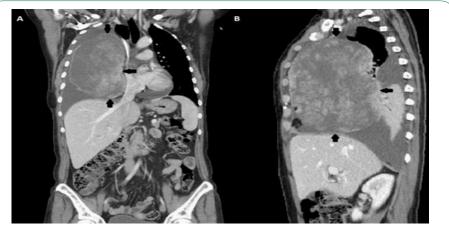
Coronal (A) and Sagittal (B) computed tomography scans, showing a bulky and heterogenous metastasis, on the right hemithorax (indicated by black arrows).
